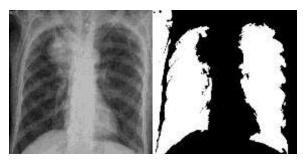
Image processing result for sample of cancer X-Ray lung image.
